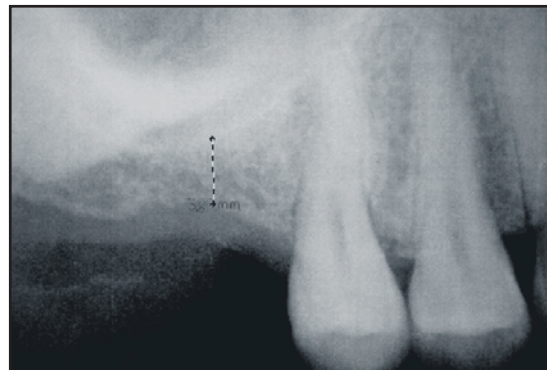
Case 3. Periapical radiograph revealed 4 mm of residual subantral bone height available to initially stabilize an implant at site #3.
